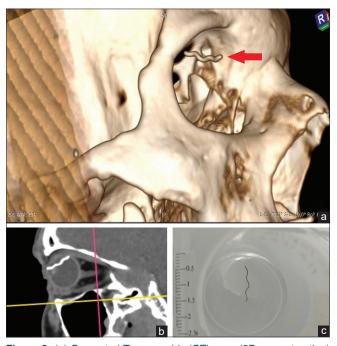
(a) Computed Tomographic (CT) scan (3D reconstruction) with the IOFB (red arrow), (b) IOFB trajectory CT scan. (c) Rotating wire brush bristle fragment
